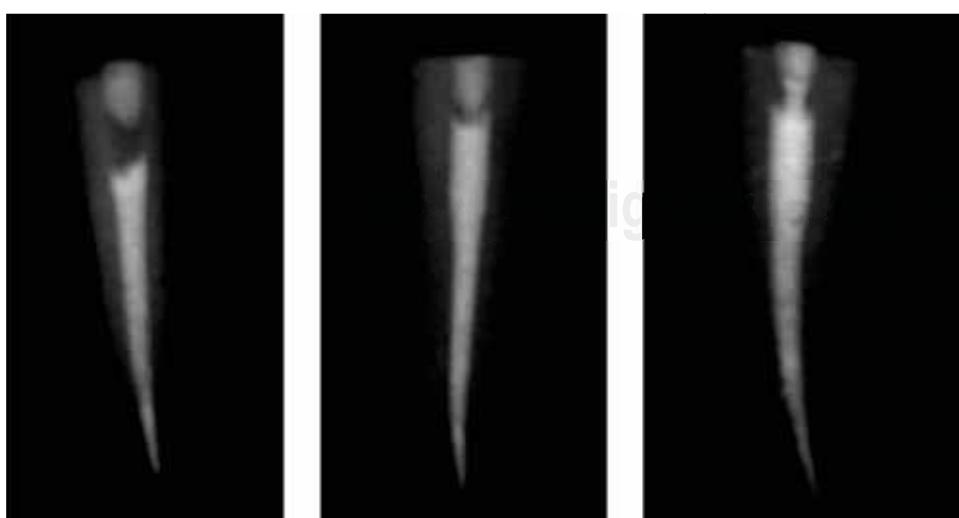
Obturation x-ray.
